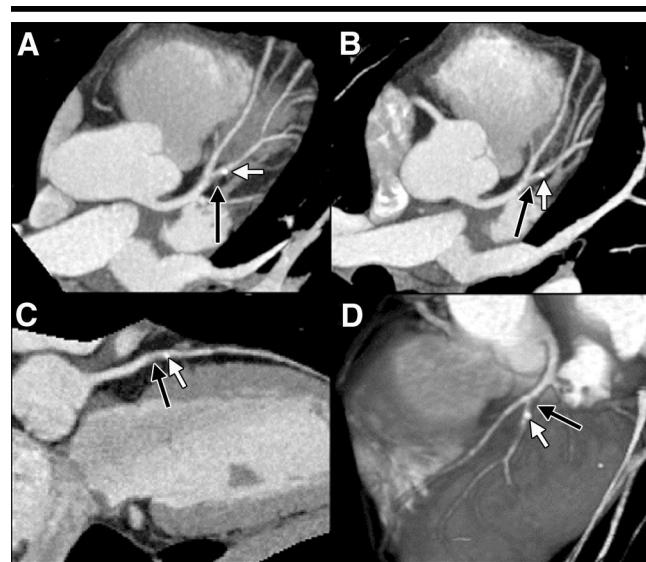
Soft, noncalcified, atherosclerotic plaque at four-detector row CT. *A*, *B*, Oblique transverse thin maximum intensity projections, *C*, craniocaudal curved multiplanar reconstruction, and *D*, left anterior oblique volume-rendered surface reconstruction demonstrate multiple noncalcified atherosclerotic plaques within the LAD coronary artery system, which result in focal arterial wall thickening with mild narrowing of the coronary lumen. Best example is noted in proximal portion of a major diagonal branch, where a prominent soft plaque (black arrows), followed by a small nodular collection of calcification (white arrows), is seen.
